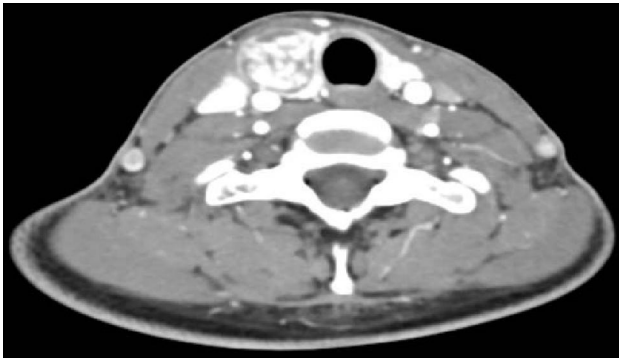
Thyroid nodule: enhancement versus calcification: 18 years old female with thyroid nodule; contrast enhanced axial CT section shows heterogeneous hyperdense lesion, however CT is not the preferred modality for evaluation of such solitary nodule of thyroid which can be better evaluated with ultrasonography.
